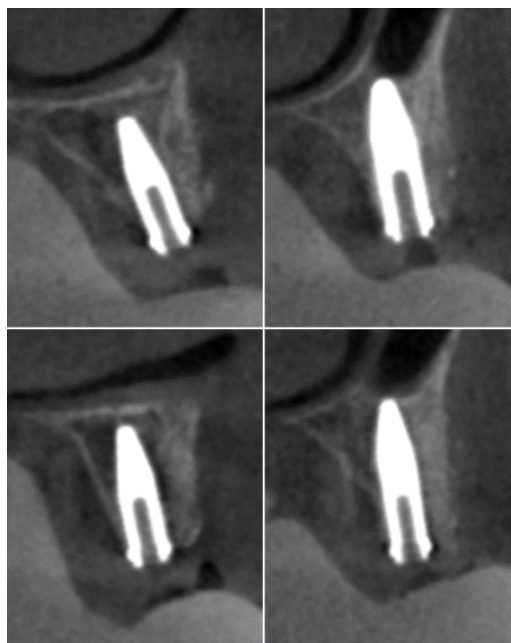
CBCT, performed at a 2-year follow-up, shows no signs of inflammation and bone resorption at the grafted sites and around implants.
